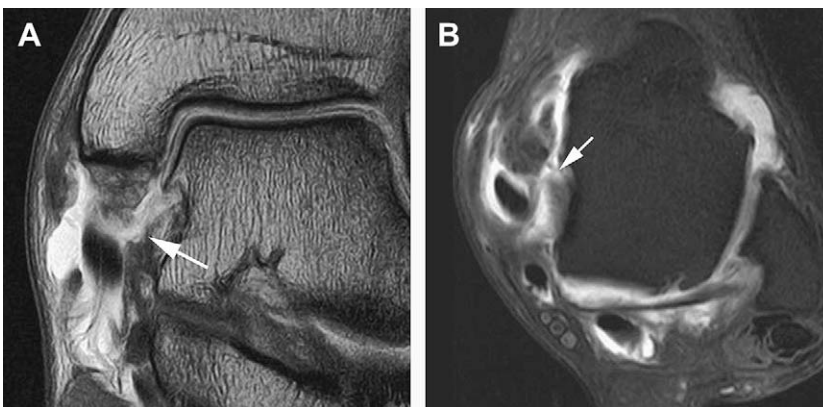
Chronic complete tear of the deltoid ligament. (A) Coronal T1-weighted and (B) axial fat suppressed T1-weighted MR arthrogram images of left ankle demonstrate complete tear of the deltoid ligament involving both superficial and deep components (arrows).
